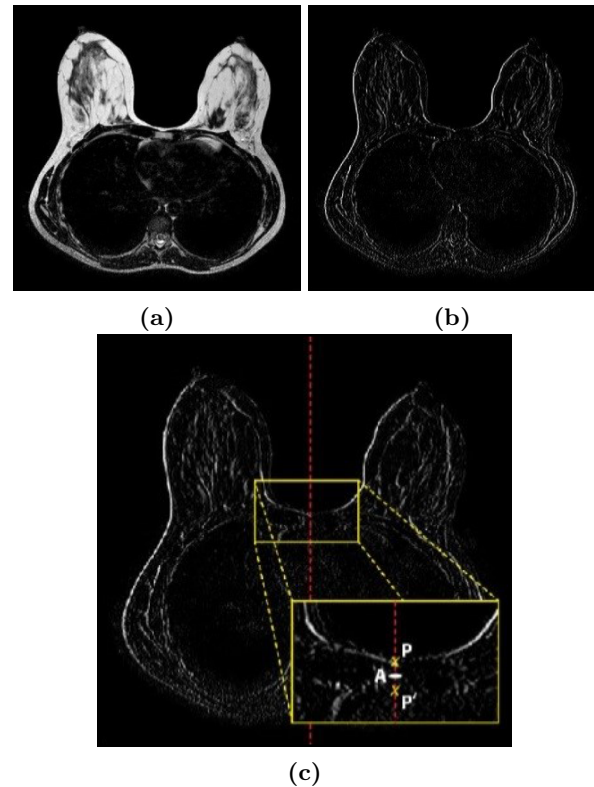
Processing procedure applied to an MRI: 2a Image acquired without CM; 2b Prewitt edge detection; 2c) Identification of point A as the midpoint of the segment P-P'
